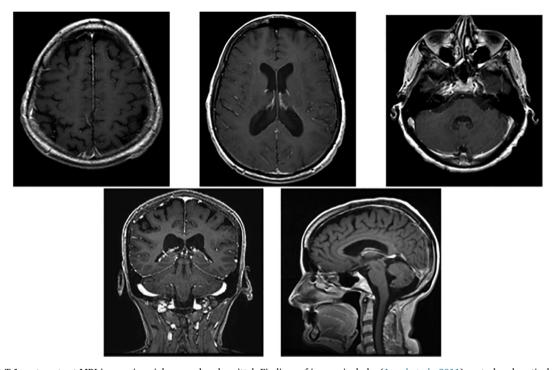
Pertinent T-1 post contrast MRI images in axial, coronal and sagittal. Findings of images include: (Jemal et al., 2011) central and cortical volume loss with widening of ventricular spaces. (Johnson, 1993) No intra-axial or extra-axial masses, abnormal enhancement or signs of increased intracranial pressure (Toyoshima et al., 2017) No pathologic enhancement after gadolinium administration.
